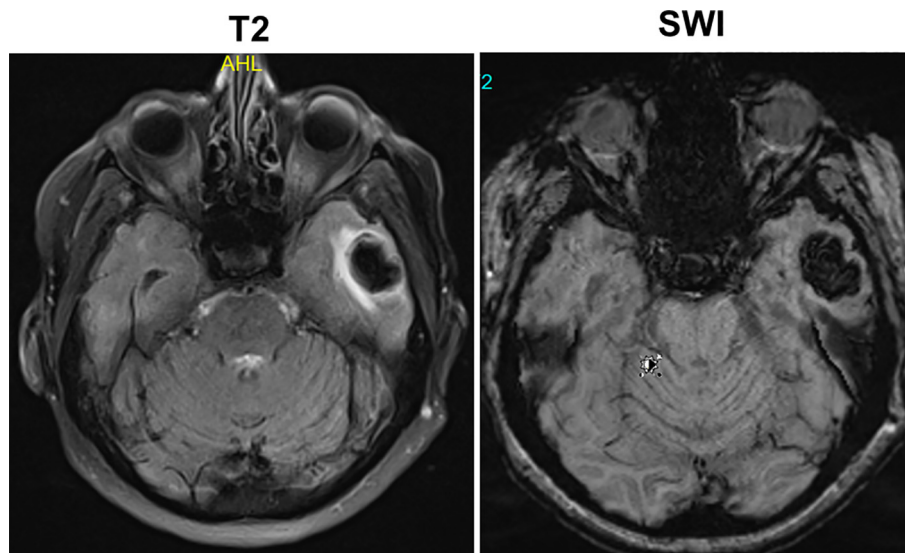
MRI showing an ICB in the left temporal lobe.
